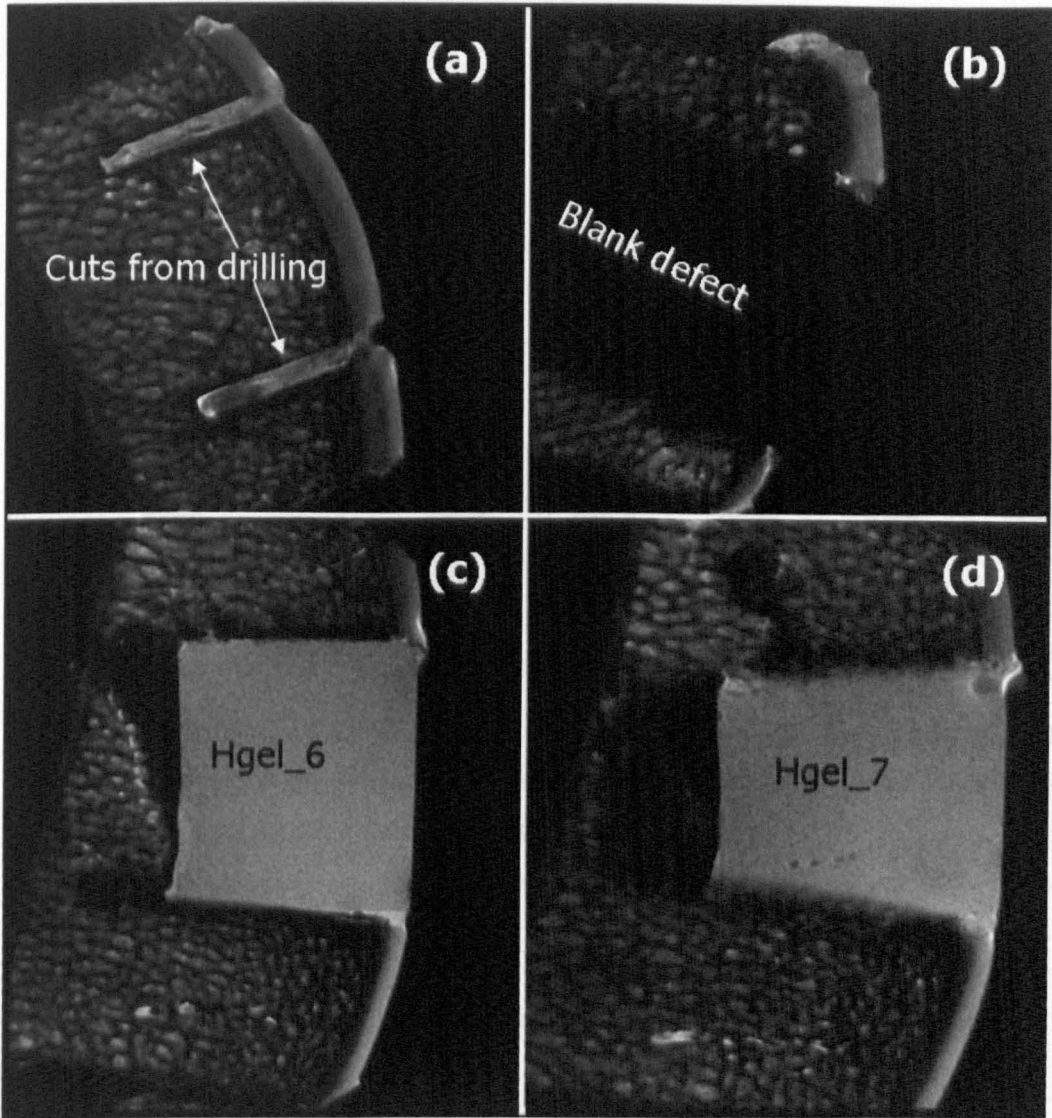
Representative μ MRI images of the femoral condyles following friction testing. (a) OC defect (b) blank defect (c&d) hydrogel defects.
